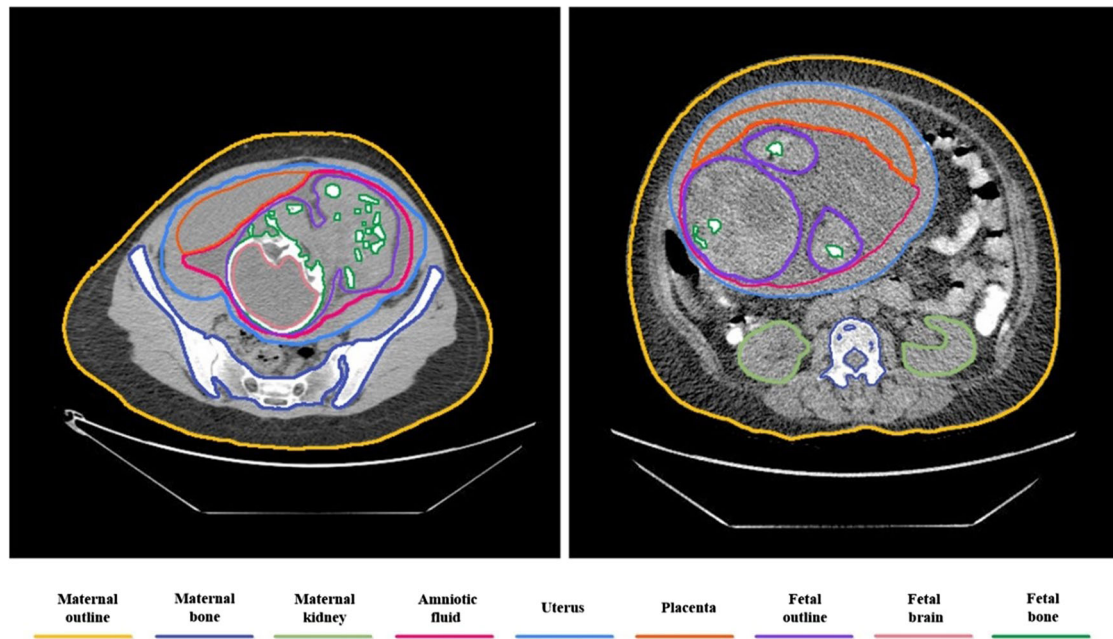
Segmentation of low-dose computed tomography (CT) images of pregnant patients into different tissue classes
